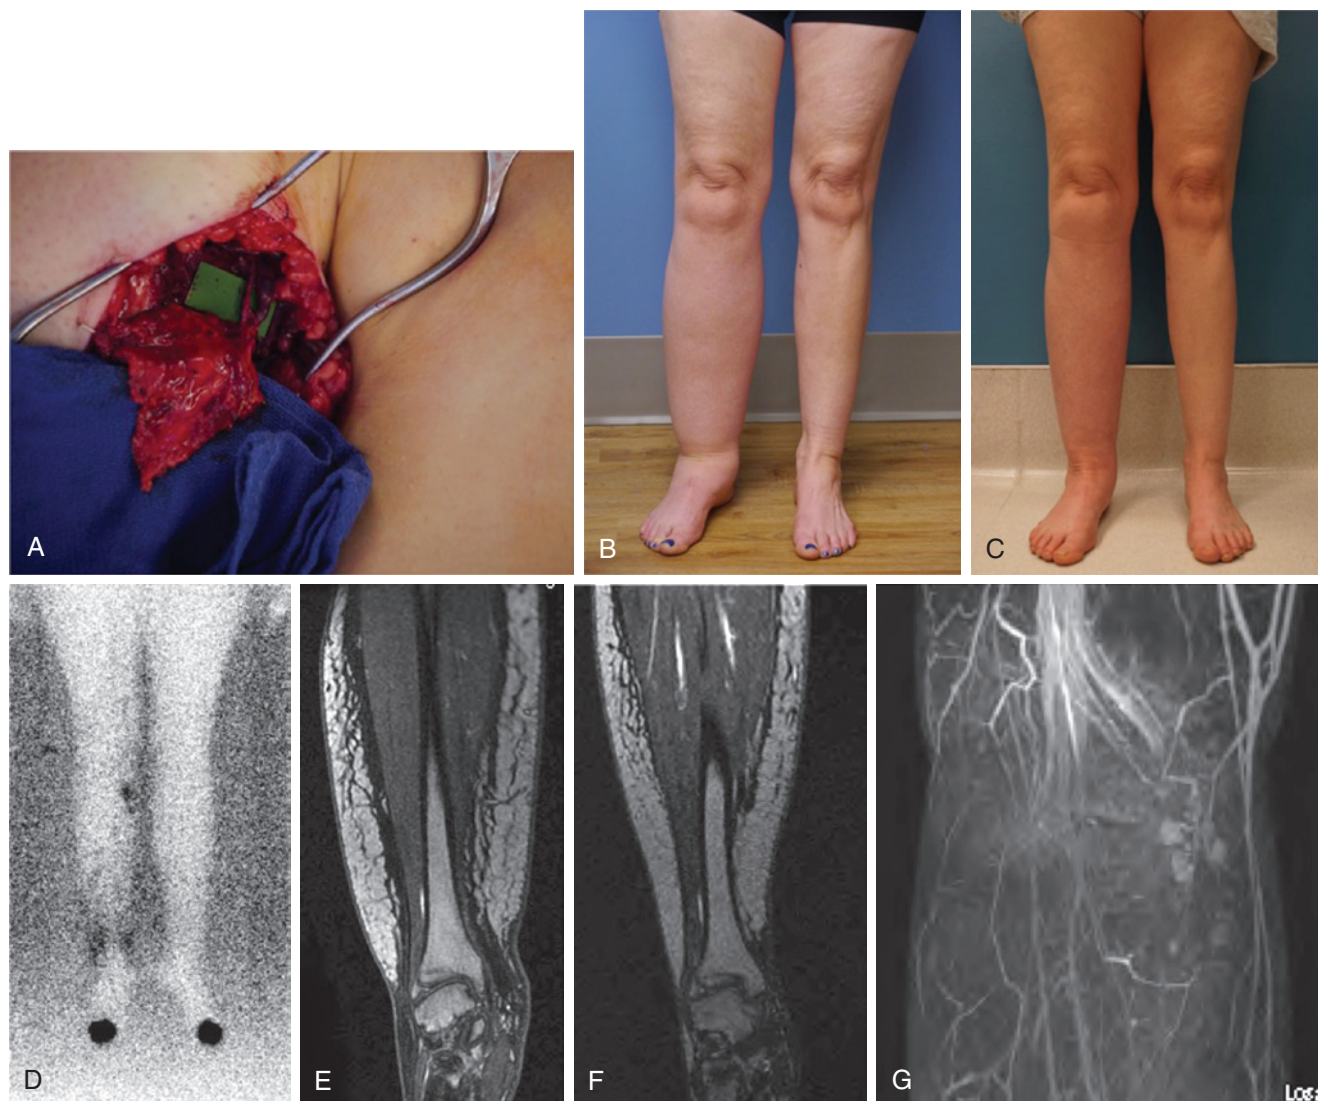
Lower extremity lymphedema treated with lymph node transfer. (A) Thoracodorsal artery-based lymph node flap to the medial sural vessels. (B) Preoperative photograph of the right lower extremity lymphedema. (C) A 1-year postoperatively following lymph node transfer to the calf. (D) Postoperative lymphoscintigraphy at 1 year, demonstrating uptake of technetium into transferred lymph nodes in the calf. (E) Preoperative MRA demonstrating approximately 50/50 contribution of fluid and fat hypertrophy to limb volume. (F) Postoperative MRA at 1 year, demonstrating reduction in fluid component but persistence of fat hypertrophy. (G) Postoperative MRA demonstrating seven viable lymph nodes at the calf recipient site.
